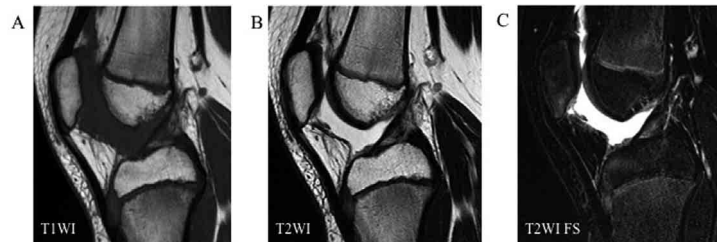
Postoperative MRI after 1 month. The mass was completely removed and there is no evidence of recurrence on T1-, T2-, or fat-suppressed T2-weighted images (A-D). Only hydroarthrosis, which may be postoperative, is apparent.
